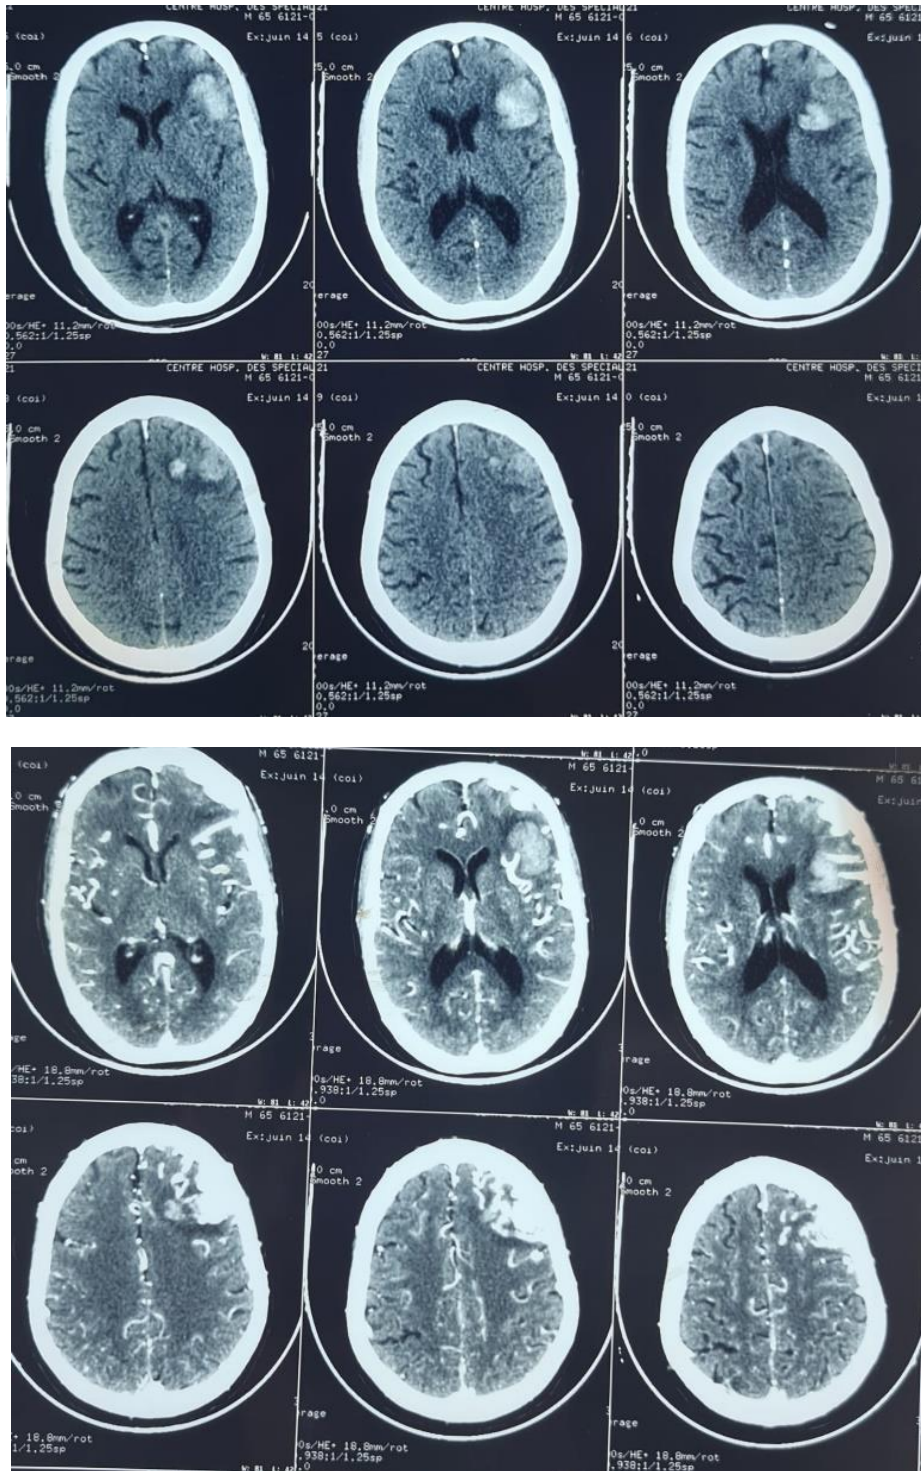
Brain CT with angiographic sequences showing a left frontal AVM
